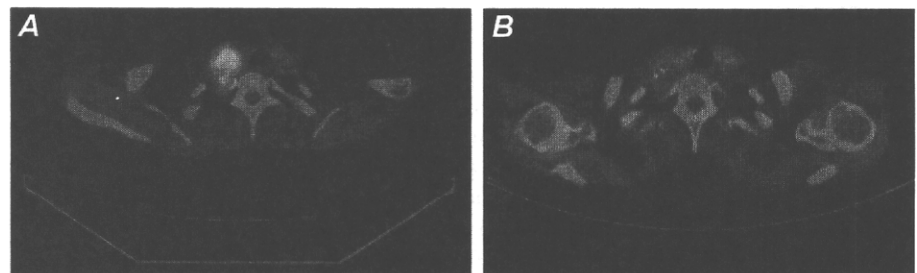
Chest computed tomography scan 1 year after boron neutron capture therapy shows shrinkage of the recurrent lesion after chemotherapy from 6.2 × 4.0 cm to 4.6 × 3.2 cm in size (25% reduction).
